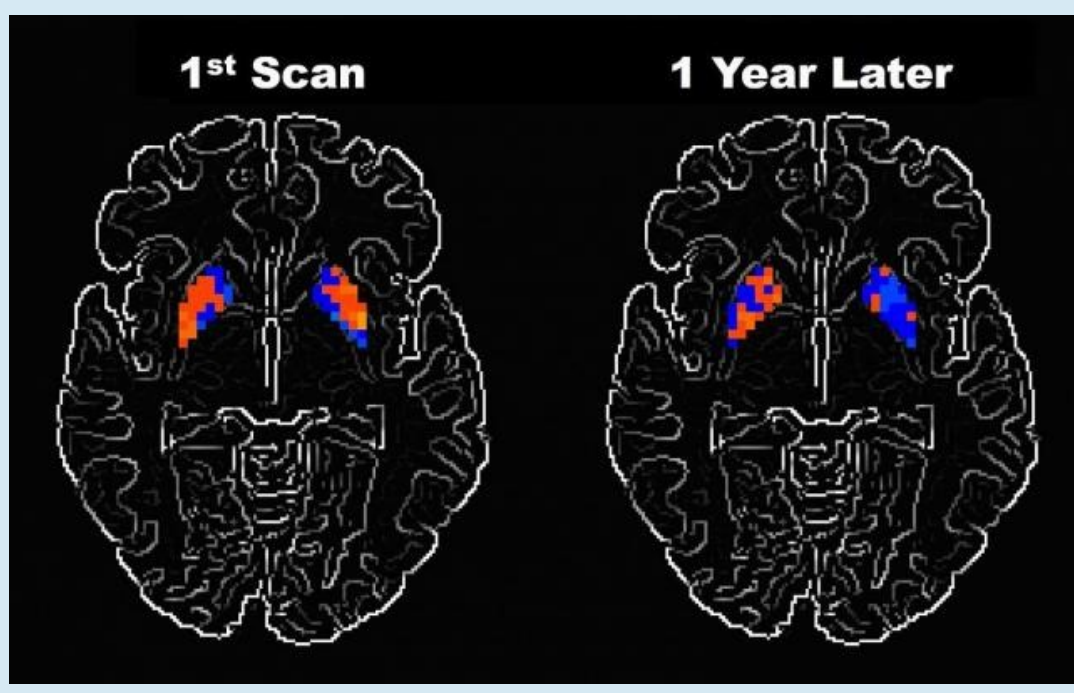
Potential ways to detect Parkinson's Disease through an MRI. (Source: PBS)
